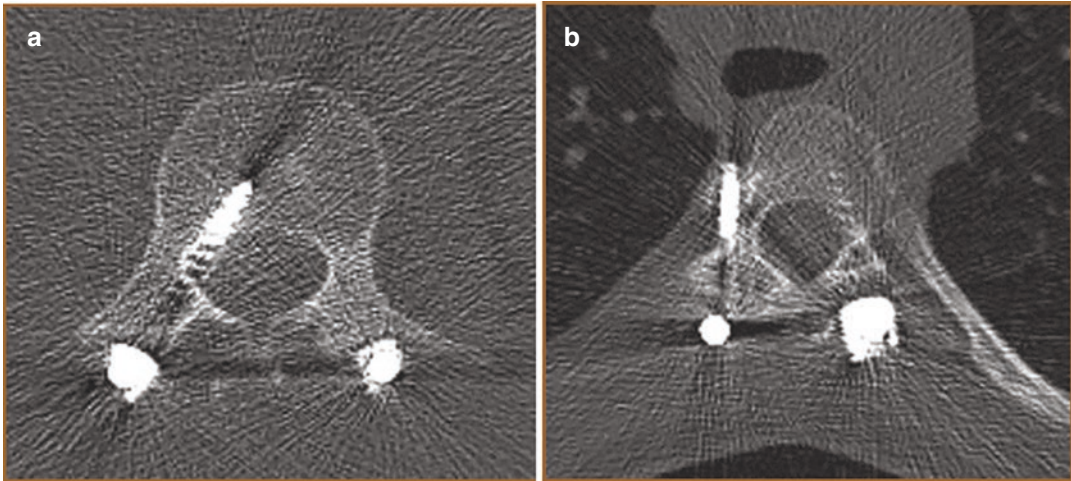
(a, b) Low-dose CT with bone windows demonstrates medial displacement of the screw (a), and in another case, lateral displacement of the screw (b) in two patients treated for scoliosis
